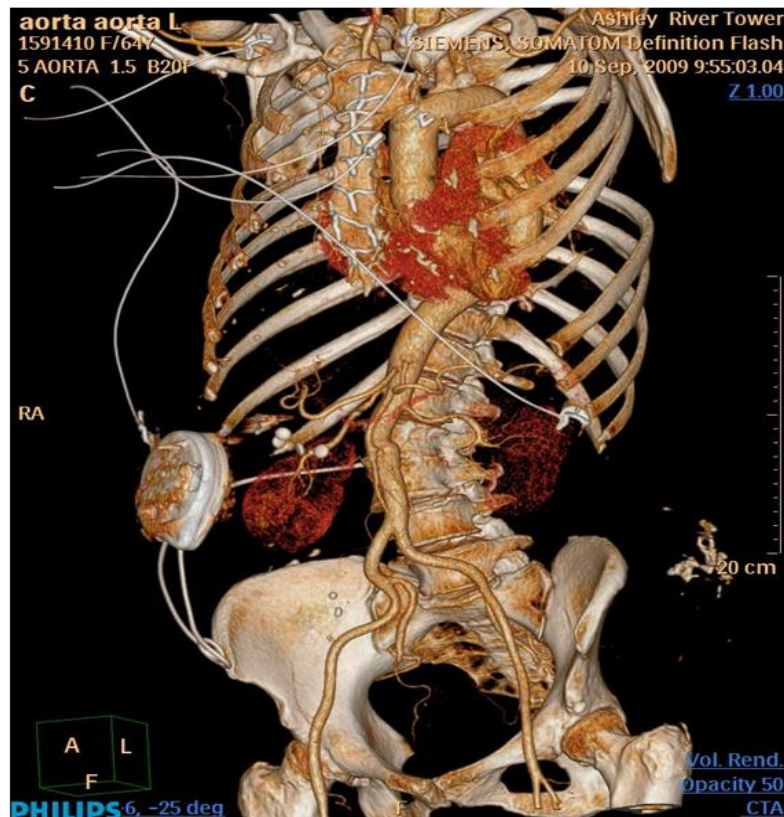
Example thoracic CTA data set. A 3D reconstruction was performed on CT data acquired after the injection of 85 ml of contrast material at 5 ml/s. The scan data was acquired in 2.5 seconds. Visible in the image are prior surgical repairs to the aorta and an implanted drug pump.
